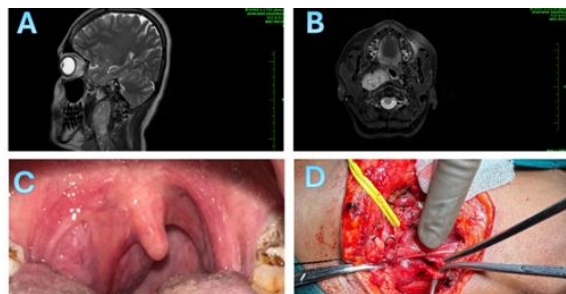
(A, B) MRI showing extent of parapharyngeal tumor. (C) Preoperative intraoral bulge. (D) Intraoperative view showing tumor arising from vagus nerve.
